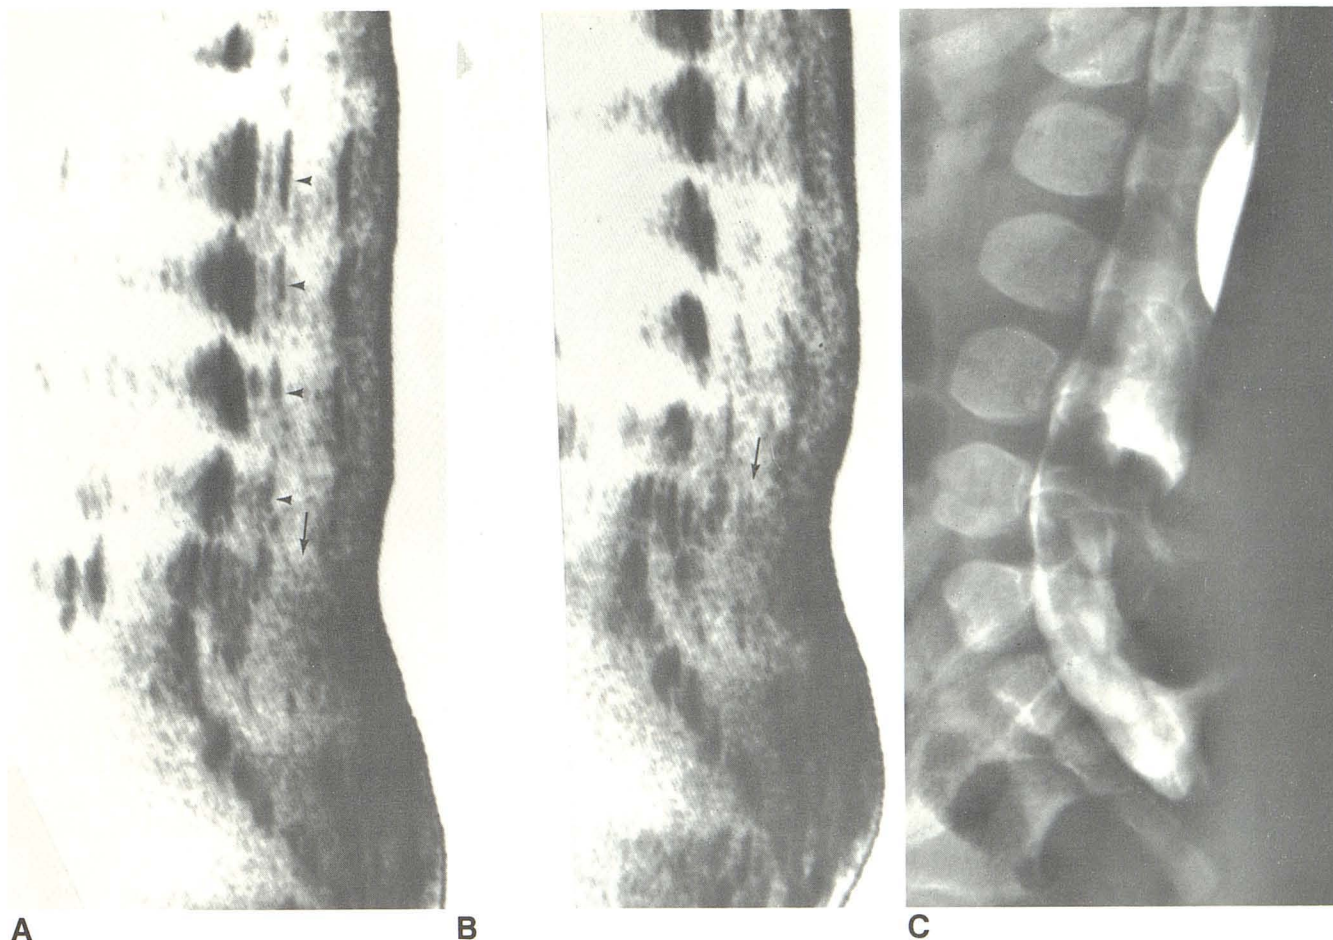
Lipomyelomeningocele with anterior displacement of tethered cord in 10-month-old boy. A and B, Midsagittal sonograms demonstrate hyperechoic skin-covered lipoma, posterior spina bifida, tethered spinal cord (*arrowheads*) displaced anteriorly by extension of hyperechoic mass (*arrows*) into canal, and increased echogenicity of distal cord, possibly representing insertion of lipoma
